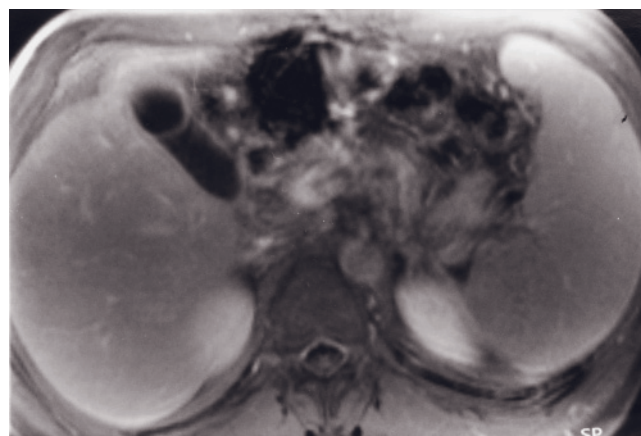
Acute cholecystitis. Transverse T2-weighted fat-suppressed echo-train spin-echo (*a*), T1-weighted GE (*b*), immediate postgadolinium GE (*c*), and 90-s postgadolinium GE (*d*) images. The wall of the gallbladder (GB) is mildly thickened (4mm) and shows increased signal intensity on the T2-weighted image (arrows, *a*). A giant hemangioma (H) is seen in *segment 6* of the liver. On the immediate postgadolinium image (*c*), increased enhancement of the gallbladder mucosa and transient increased enhancement of liver parenchyma adjacent to the gallbladder is apparent (arrow, *c*). On the 90-s postgadolinium image (*d*), increased enhancement of the entire gallbladder wall (arrows, *d*) is shown. Also note the peripheral nodular enhancement of the hemangioma (H).
